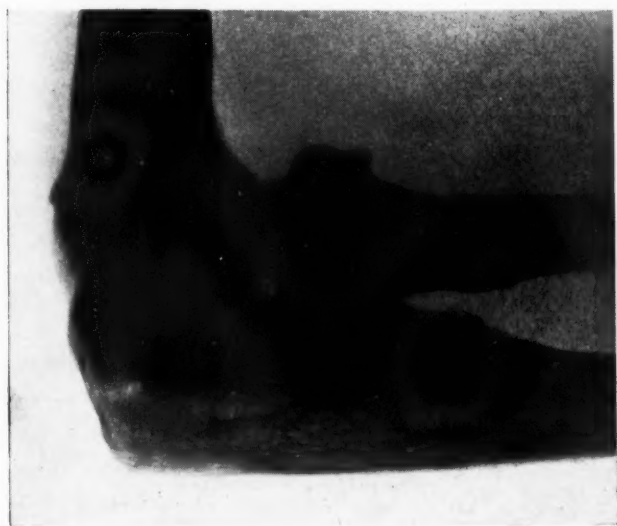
Lateral roentgenogram shows diminution in the joint space and irregularity of the articular surfaces, indicative of osteoarthritis of the elbow joint.
